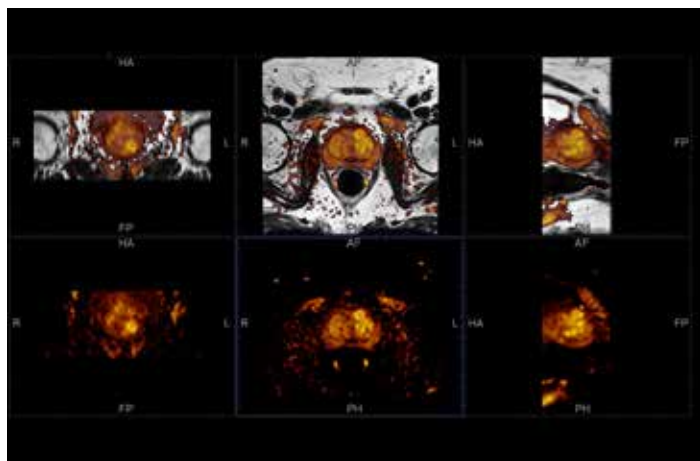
Updating and superimposing mpMRI images in a UroFusion environment. The primary image is represented by the axial axis of the Weighted T2 series and the secondary by the DWI series.
